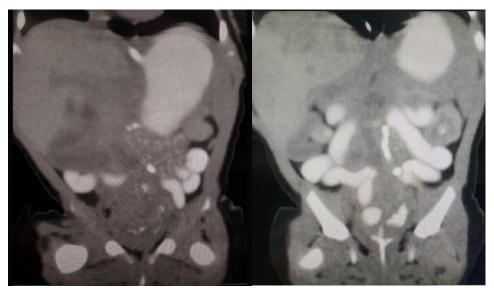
A coronal section of the abdominal CT scan with contrast showed a dilated stomach and megaureter.
